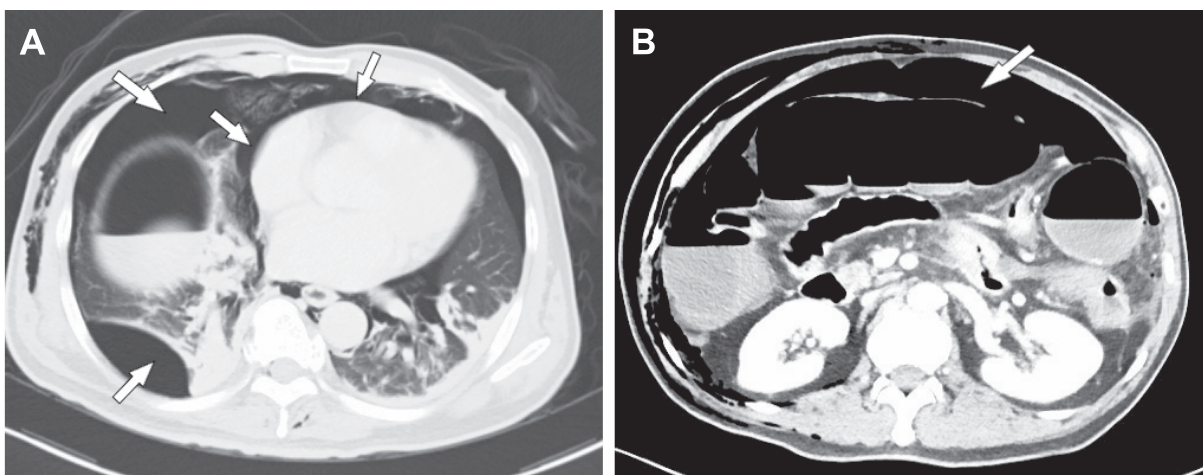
Computed tomography scanning of the (A) chest, and (B) abdomen for diagnosis of extraperitoneal colon perforation. Note massive air collections in the mediastinum, pericardium, pleural spaces, peritoneum, and colon (white arrows).
